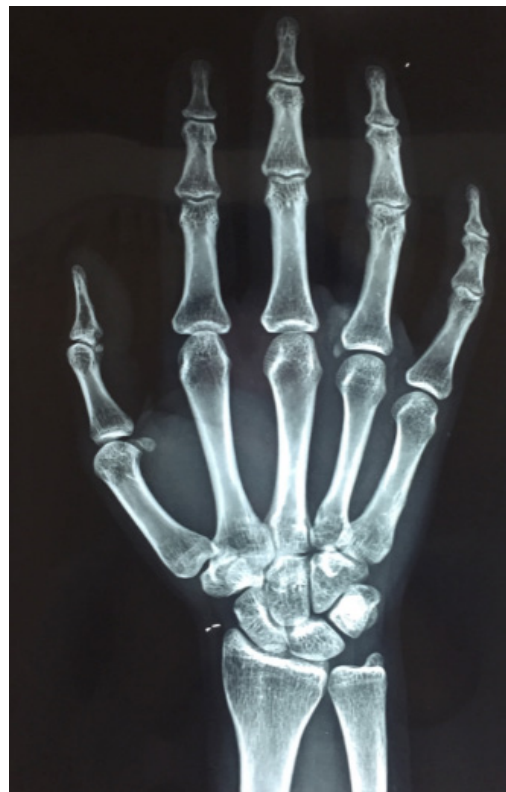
X-ray of the hand showed calcification over the volar aspect of the 4th metacarpophalangeal joint.
